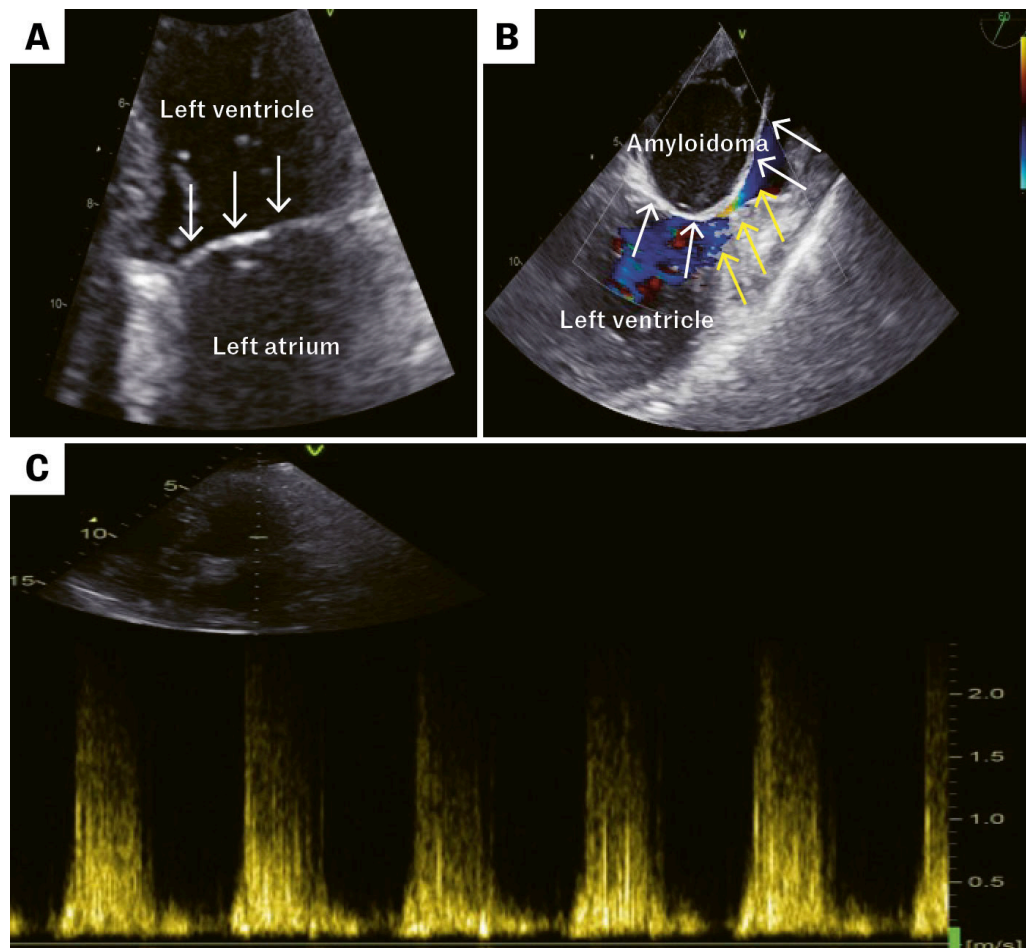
Echocardiography. a) Transthoracic echocardiographic image showing a bridge-like structure (white arrows) near the mitral valve. b) Transoesophageal image with colour Doppler demonstrating blood flow (yellow arrows) adjacent to the atrial mass. c) Transthoracic continuous-wave Doppler measurement across the mitral valve outflow, showing high velocities and elevated pressure gradients.
